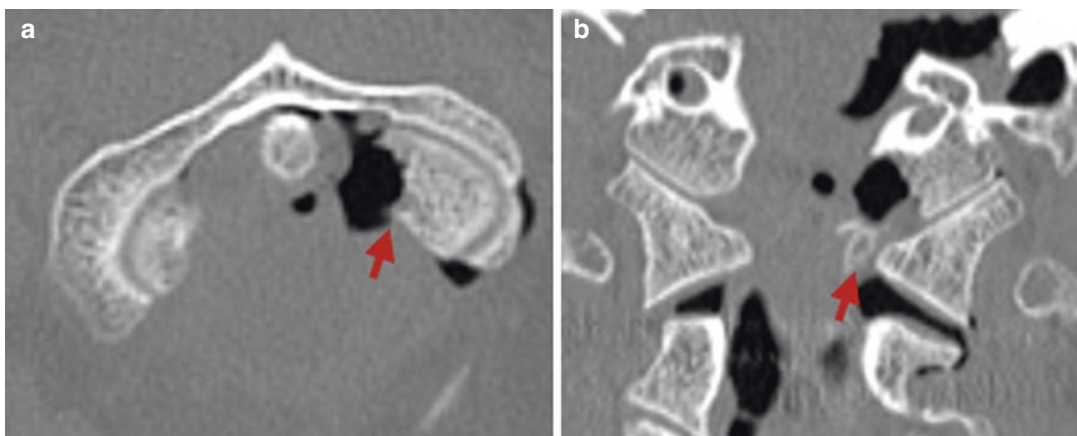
(a) Axial and (b) coronal computed tomography of an occipital condyle fracture. A small bone tip (arrow) deviation into the spinal canal can be observed
